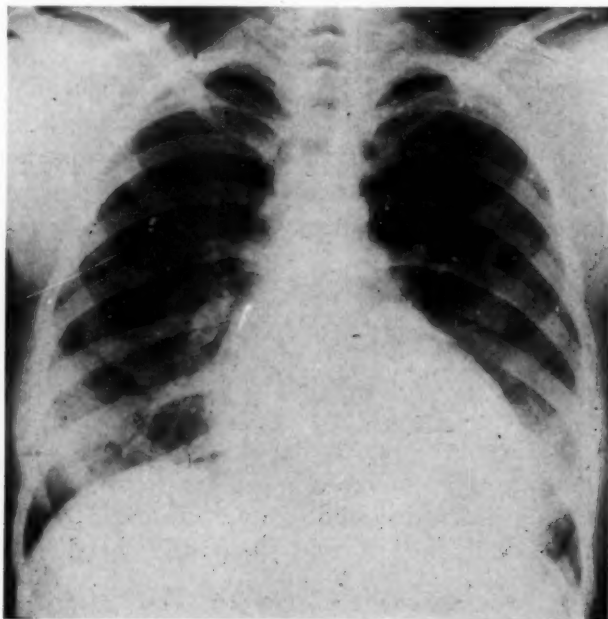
Roentgenogram of Patient P. D., showing moderate cardiomegaly and normal pulmonary vasculature. This 13-year-old girl has the WPW syndrome and familial cardiomegaly, but is presently asymptomatic.
